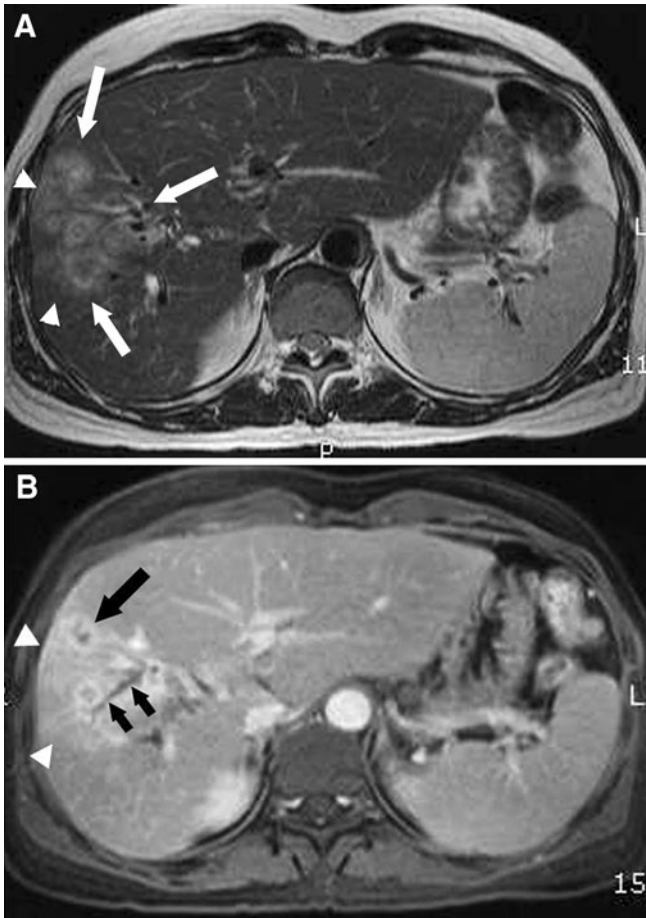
Hepatic abscess associated with RPC in a 53-year-old man who complained of abdominal fever and leukocytosis. He had a history of recurrent attacks of cholangitis. A T2-weighted TSE MR image shows multiple small lesions in the anterior segment of the right lobe (*arrows*) with peritumoral regional high-signal intensity (*arrowheads*). B Contrast-enhanced MR images during the portal phase demonstrate multilayered target-like enhancement of the mass (*large arrow*). There are transient signal intensity differences at the same site as peritumoral regional high-signal intensity on T2WI (*arrowheads*). Note thrombosis at the branches of middle hepatic vein (*small arrows*). This mass was confirmed as an abscess by aspiration.
